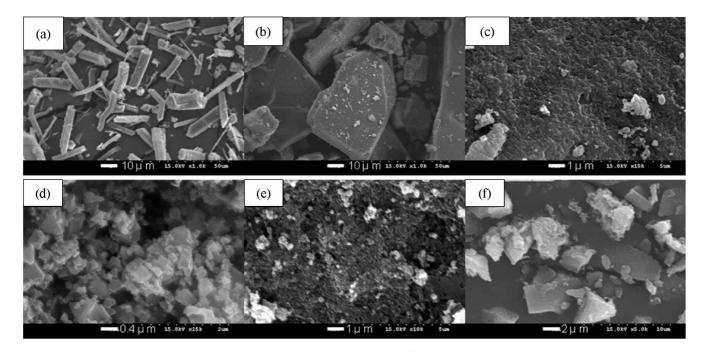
SEM images of Cu-BTC samples synthesized by ultrasonic irradiation for 1 min with different DMF concentrations in the solvent of water (4 mL) - ethanol (2 mL) - DMF(x mL): (a) 0.0 mL (Sample E); (b) 0.2 mL (Sample F); (c) 0.5 mL (Sample G); (d) 1.0 mL (Sample A); (e) 3.0 mL (Sample H) and (f) 6.0 mL (Sample I). The scale bars for (a), (b), (c), (d), (e) and (f) correspond to 10, 10, 1, 0.4, 1 and 2 μ m, respectively.
